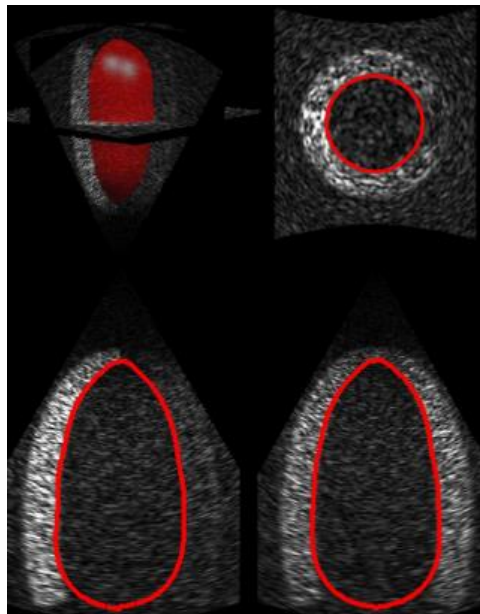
3D endocardium segmentation in echocardiography image [44].
